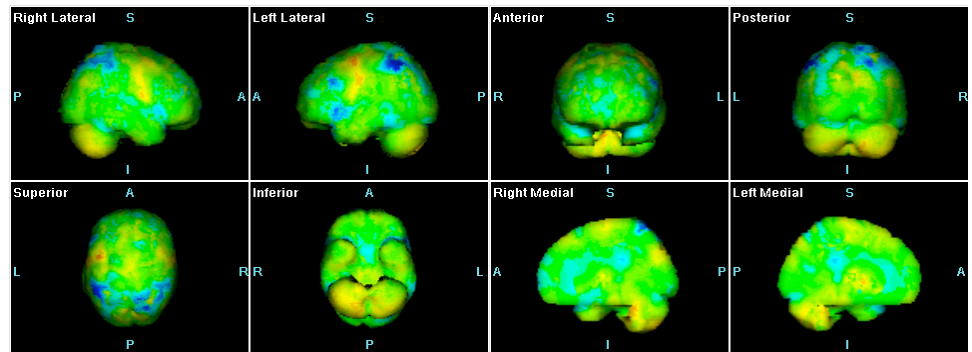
Stereotactic surface projection of statistics image for a FDG-PET case. The area of reduced uptake in the region of the parietal lobe visible in Figure 10 appears as an area of negative statistics (blue).
